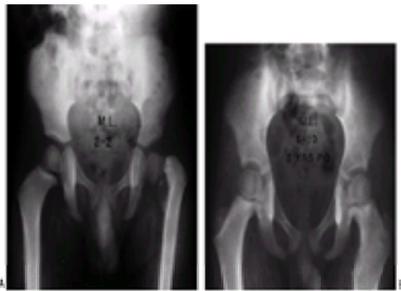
Anteroposterior pelvic radiographs of a boy 2 years, 2 months of age, with developmental coxa vara. A: Preoperative radiograph. B: Postoperative radiograph. A subtrochanteric derotational proximal femoral osteotomy successfully achieved the objectives of surgical correction, including correction of the varus angulation into a physiologic range, changing the loading characteristics of the femoral neck from shear to compression by achieving a physeal angle of 30 degrees or less, and reestablishing a proper abductor muscle length–tension relation.
